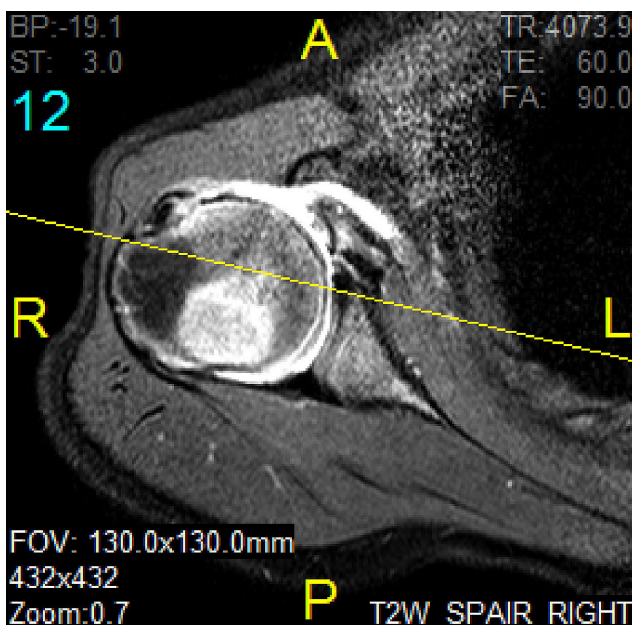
T₂-weighted axial magnetic resonance imaging shows complete subscapularis rupture.
